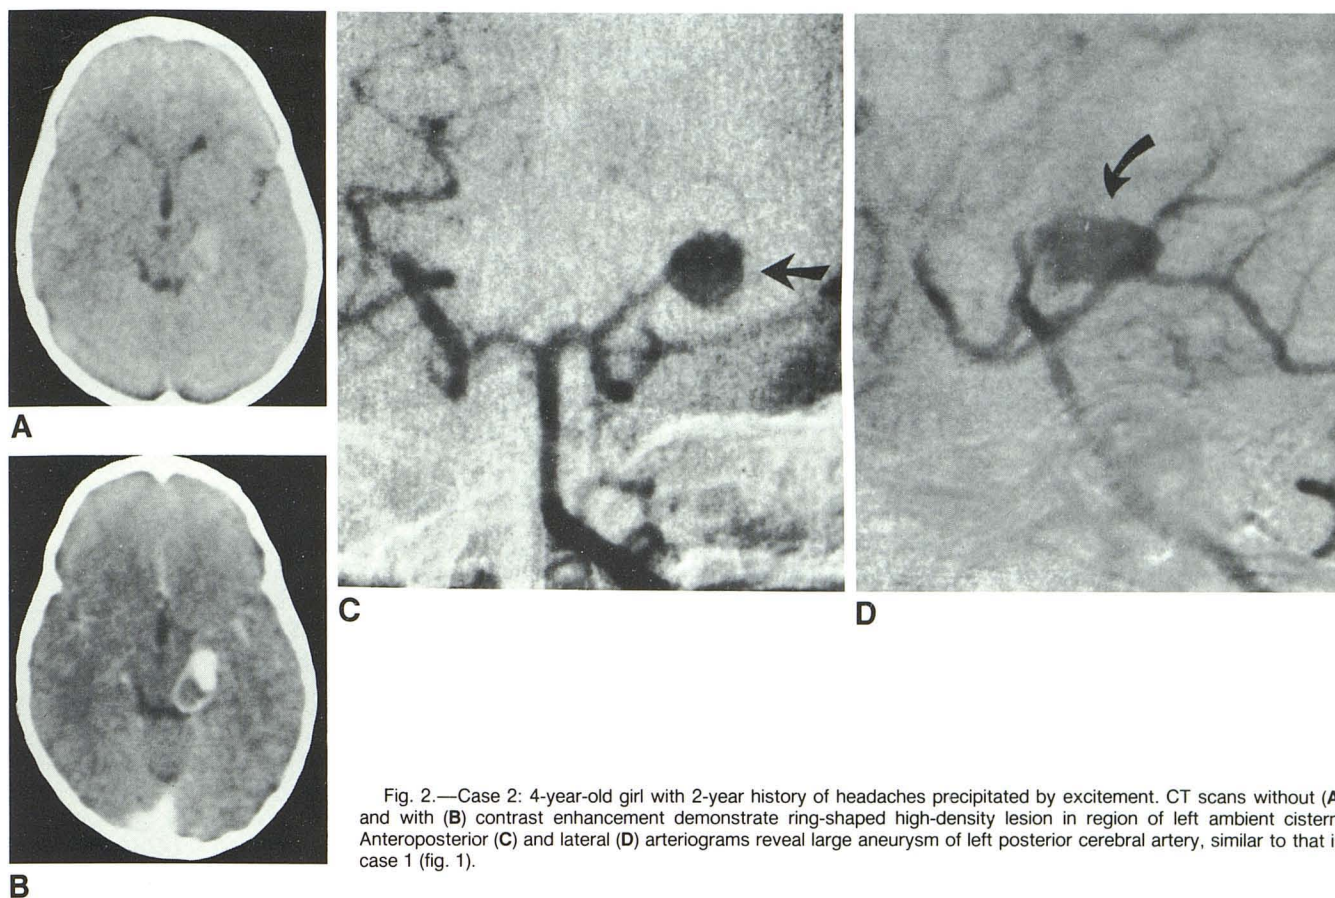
Case 2: 4-year-old girl with 2-year history of headaches precipitated by excitement. CT scans without (A) and with (B) contrast enhancement demonstrate ring-shaped high-density lesion in region of left ambient cistern. Anteroposterior (C) and lateral (D) arteriograms reveal large aneurysm of left posterior cerebral artery, similar to that in case 1 (fig. 1).
